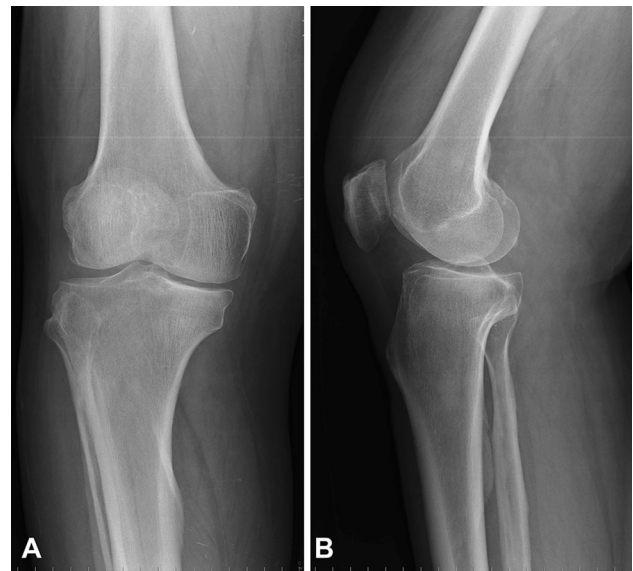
Pre-operative radiograph: a Frontal view, b lateral view
